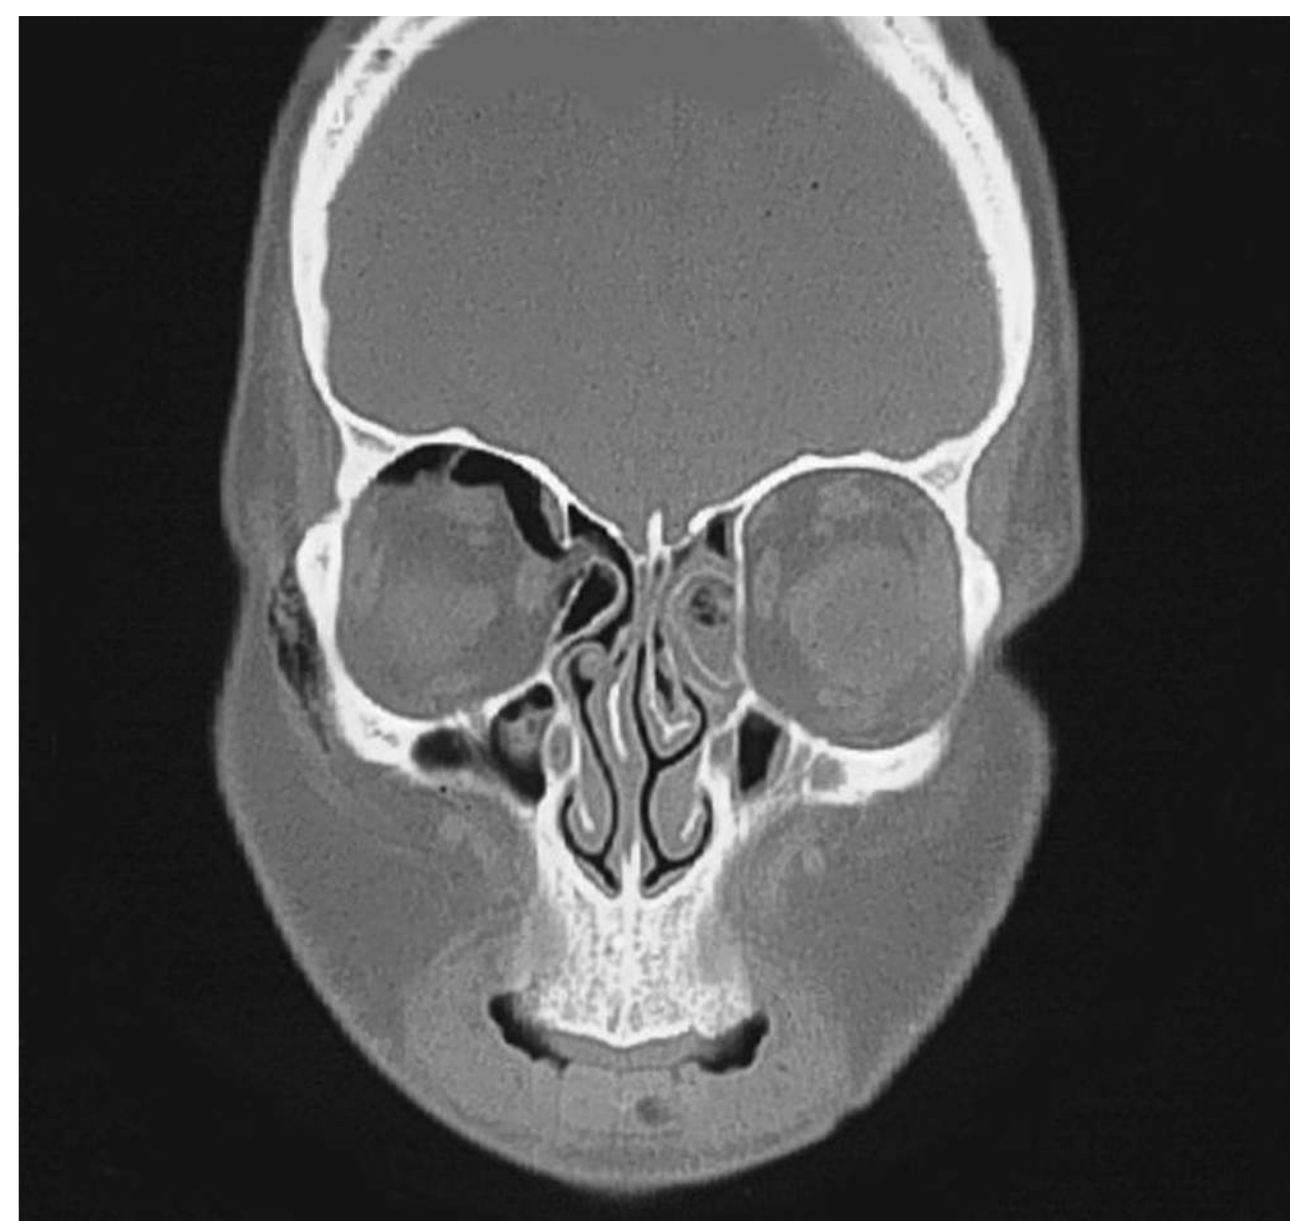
■ CT of Medial Wall Orbital Fracture. Coronal CT of the patient in Fig. 1.26. Subcutaneous emphysema and orbital air is seen. An opening between the orbit and ethmoid air cells can be seen. (Photo contributor: Lawrence B. Stack, MD.)
